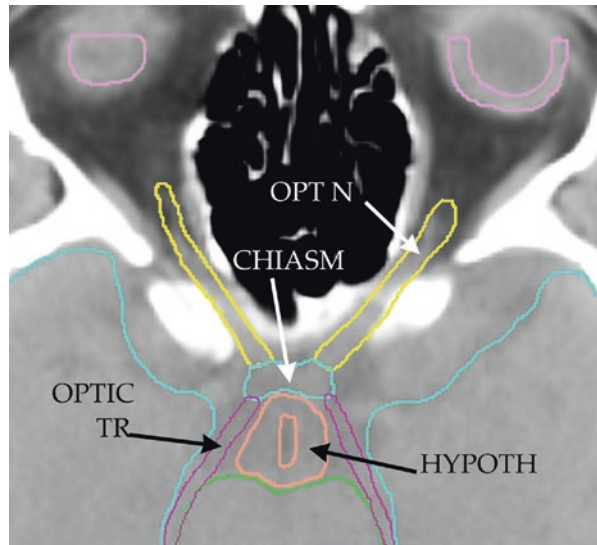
This more inferior axial slice shows the retinas (RET) and the optic nerves (OPT N). The optic nerves are not connected to the eyes in this section and approach the sphenoid bone posterior to the orbit. Because of the angle of the CT scan, the optic nerves are also not connected to the chiasm in this section. The optic tracts (OPT TR) extend posteriorly from the chiasm. The hypothalamus (HYPOTH) is located on either side of the third ventricle as seen also in Fig. 1.4c. The anterior temporal lobes are shown in the most lateral portion of the brain (cyan)
